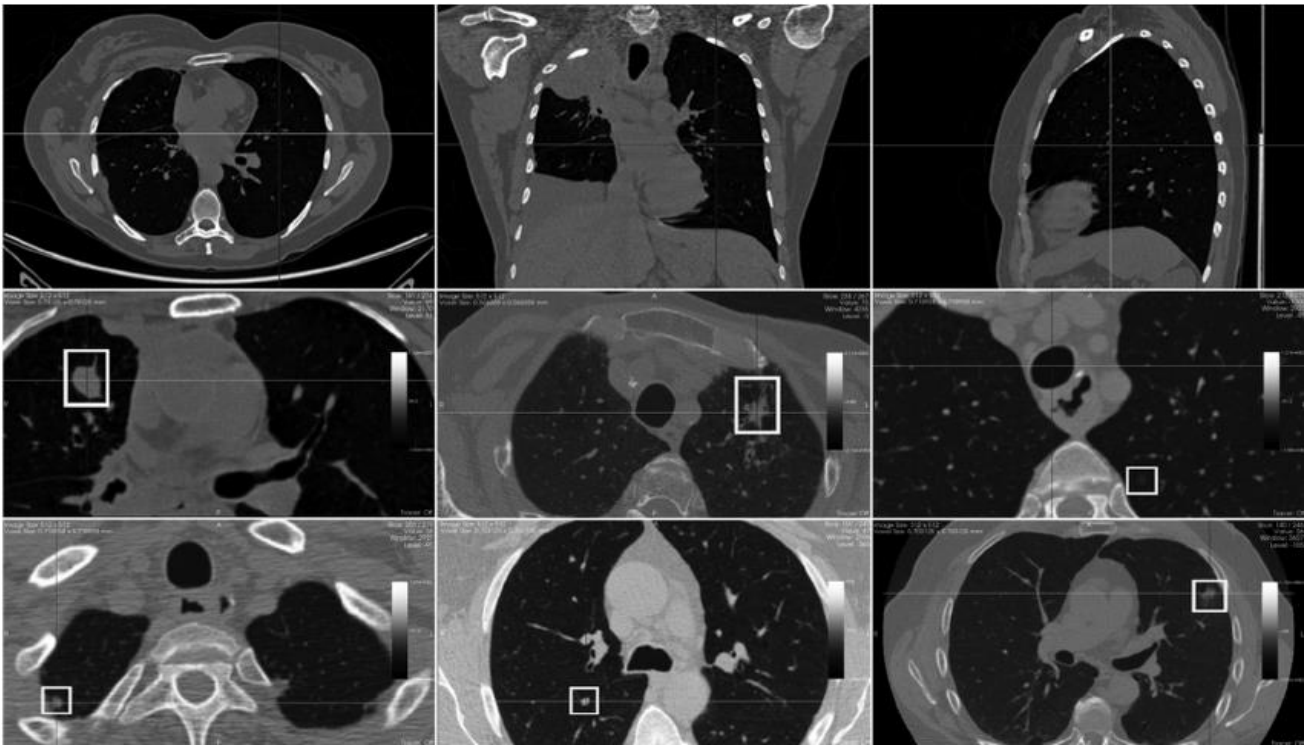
AI-enhanced CT image highlighting tumor features.
